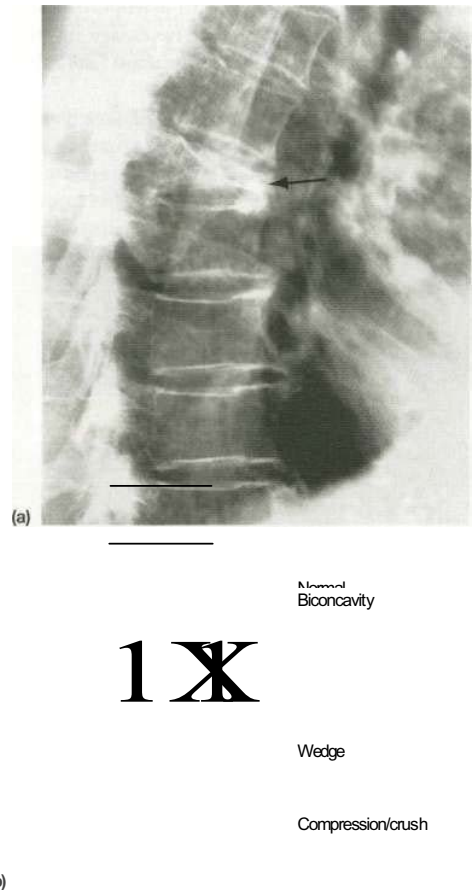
(a) Lateral X-ray of the thoracic spine showing a compression fracture (arrowed), (b) Types of vertebral deformity in osteoporosis.
